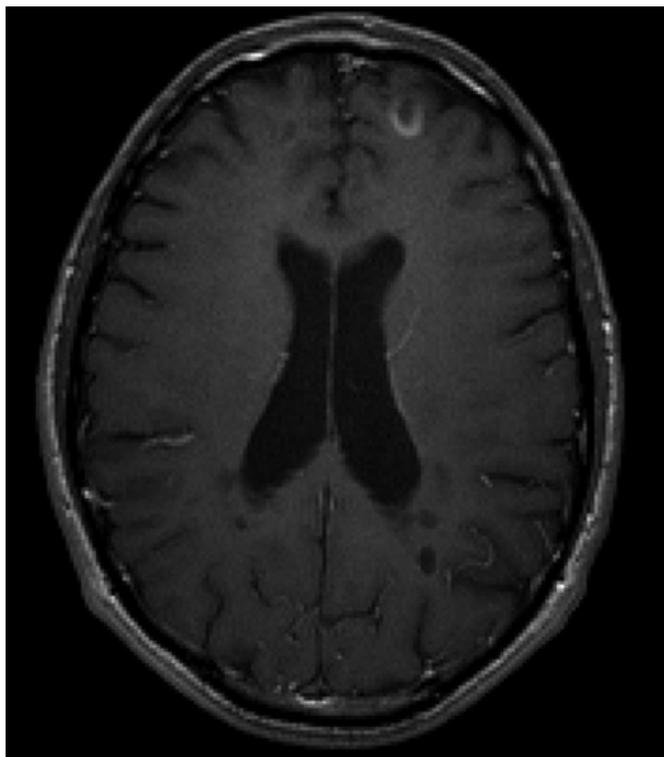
Axial T1-weighted with contrast image of a patient with MS demonstrate open ring sign in the left frontal lobe.
